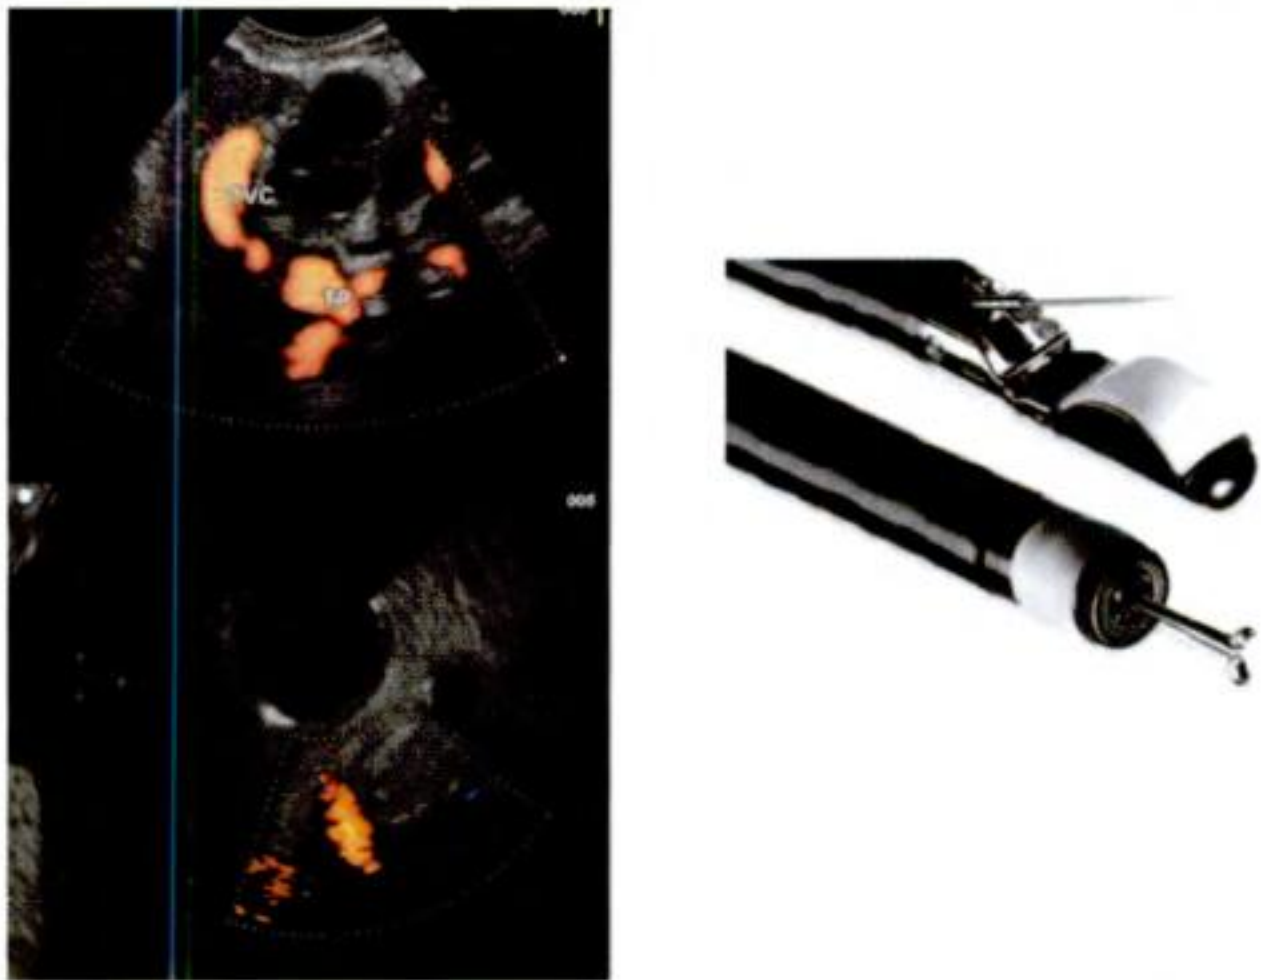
Ultrasound endoscopy linear array and radial scanning Pentax systems.
